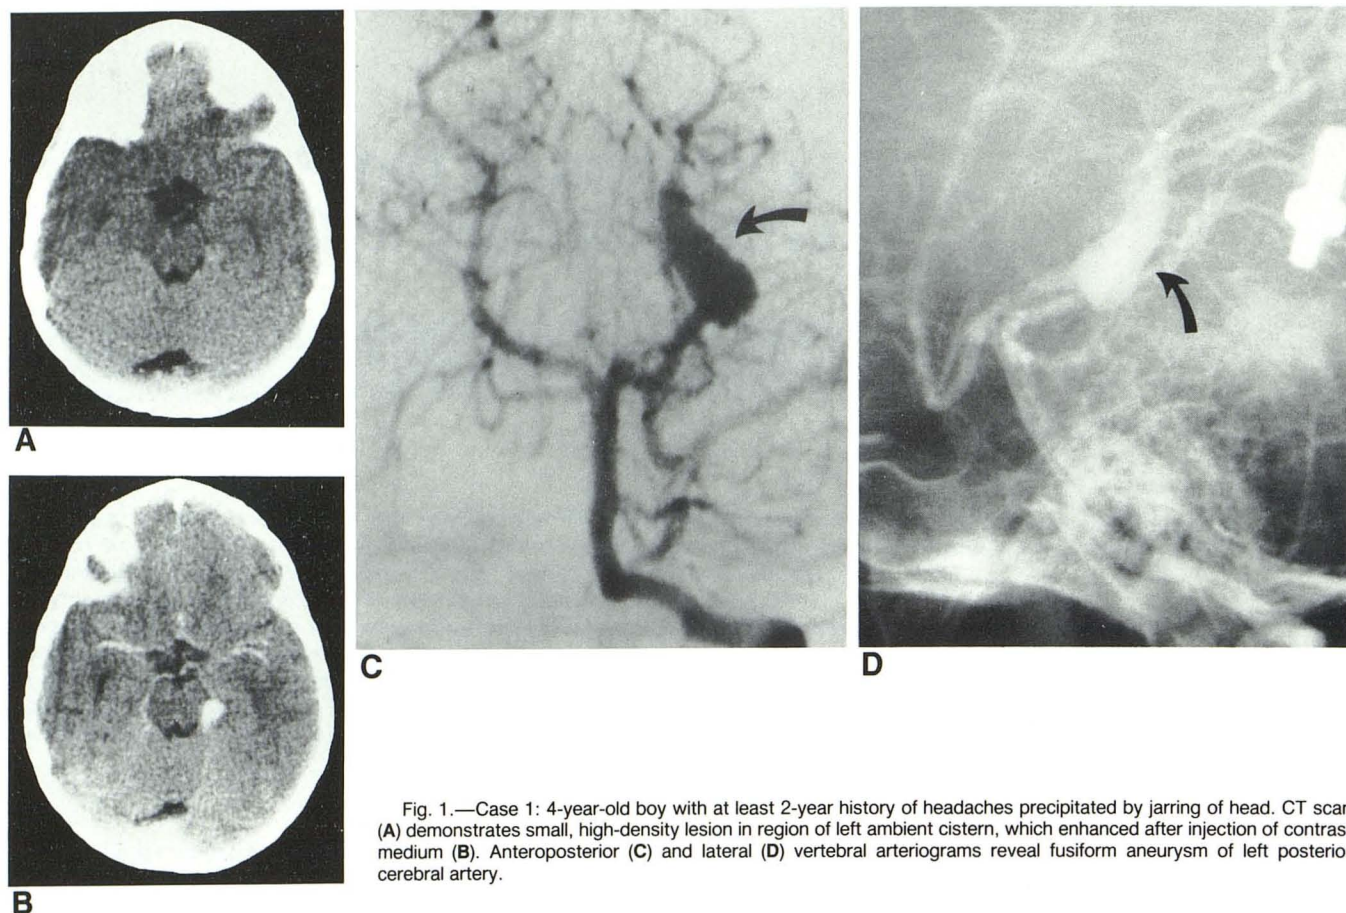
Case 1: 4-year-old boy with at least 2-year history of headaches precipitated by jarring of head. CT scan (A) demonstrates small, high-density lesion in region of left ambient cistern, which enhanced after injection of contrast medium (B). Anteroposterior (C) and lateral (D) vertebral arteriograms reveal fusiform aneurysm of left posterior cerebral artery.
